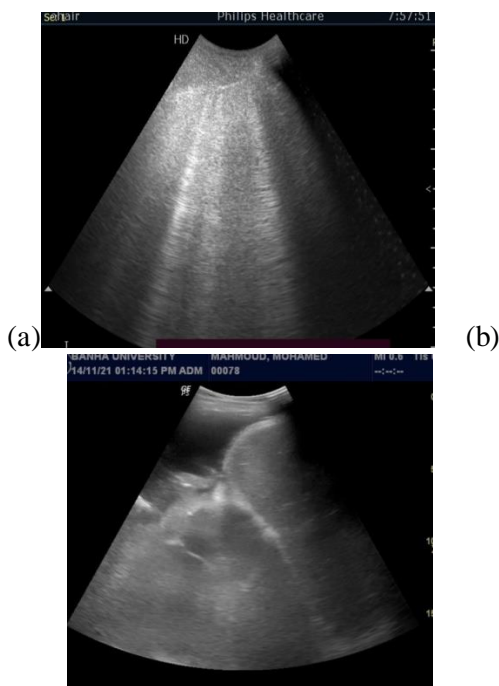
Ultrasound findings in a patient presented with acute CPE showing a) Homogenous AIS (B lines), no pleural line abnormalities, and no consolidations were present. b) Showing the presence of a moderate amount of pleural effusion.
